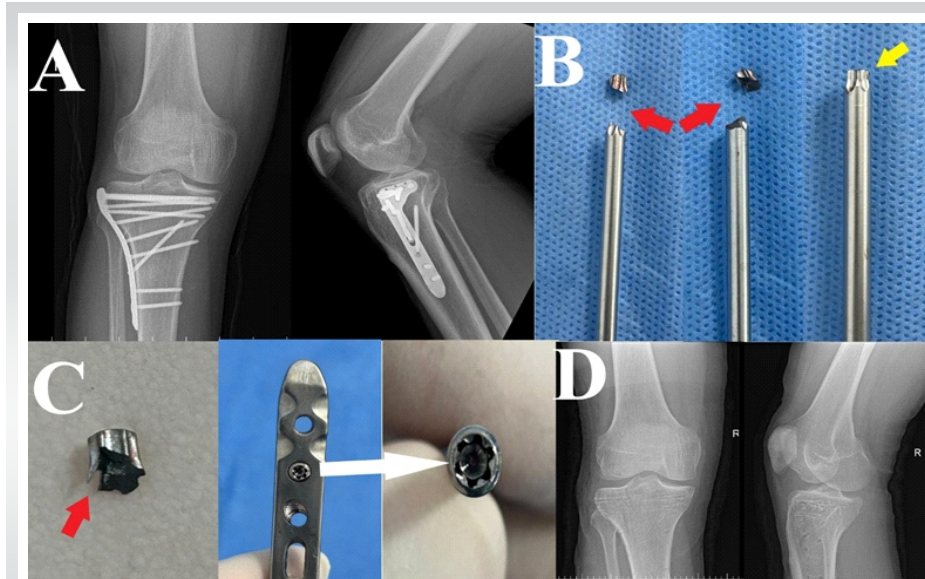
(a) pre-operative plain radiograph of the knee and proximal tibia (anteroposterior and lateral views) showing healed tibial plateau fracture fixed with proximal tibial locking plate and screws. (b) clinical images showing the broken screwdriver tip (red arrowheads) compared to an intact one (yellow arrowhead). (c) magnified image of the broken screwdriver tip (red arrowhead), and the plate and screws after removal showing a visually intact screw head (white arrow). (d) post-operative plain radiographs showing removal of all the retained hardware.
